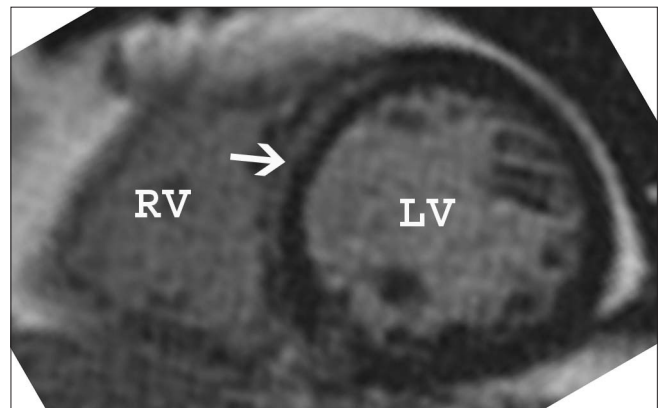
Non-ischemic dilated cardiomyopathy. Short-axis delayed-enhancement magnetic resonance imaging demonstrates a dilated left ventricle with linear mid-myocardial scarring in the basal septum (arrow); this is a characteristic pattern seen in non-ischemic dilated cardiomyopathy. The coronary arteries were normal in this patient
